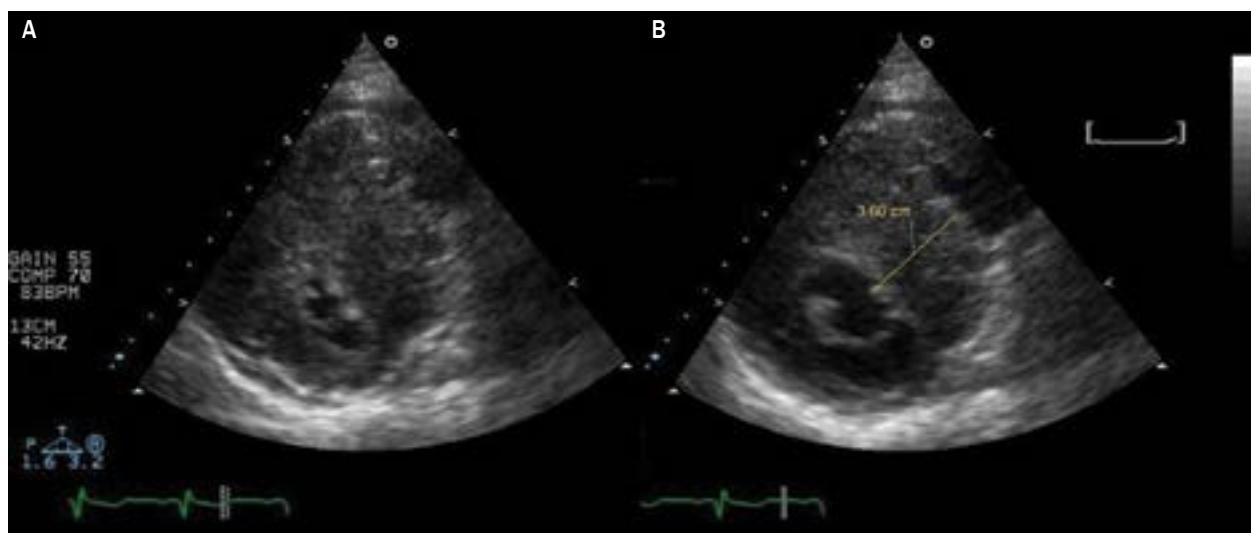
Echocardiographic view
